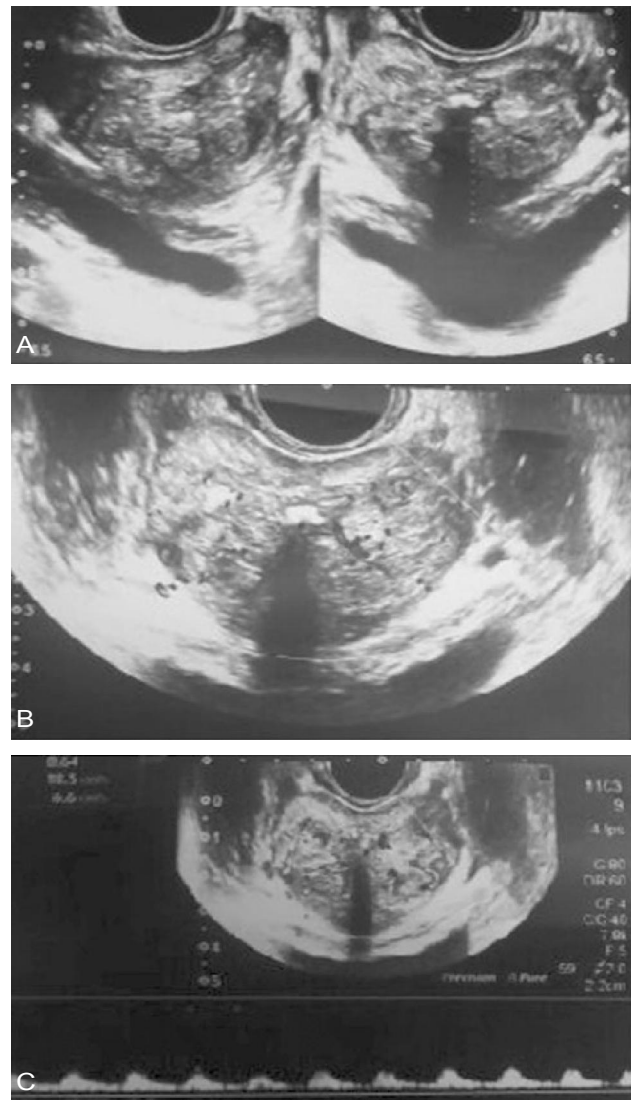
A 60 year old male with urinary retention. (A) Enlarged prostate gland showing heterogenous echotexture and calcification with hypo and hyperechoic nodule in peripheralzone. (B) These nodules show vascularity on color doppler. (C) The corresponding hypoechoic nodule showing arterial flow on pulse doppler.
